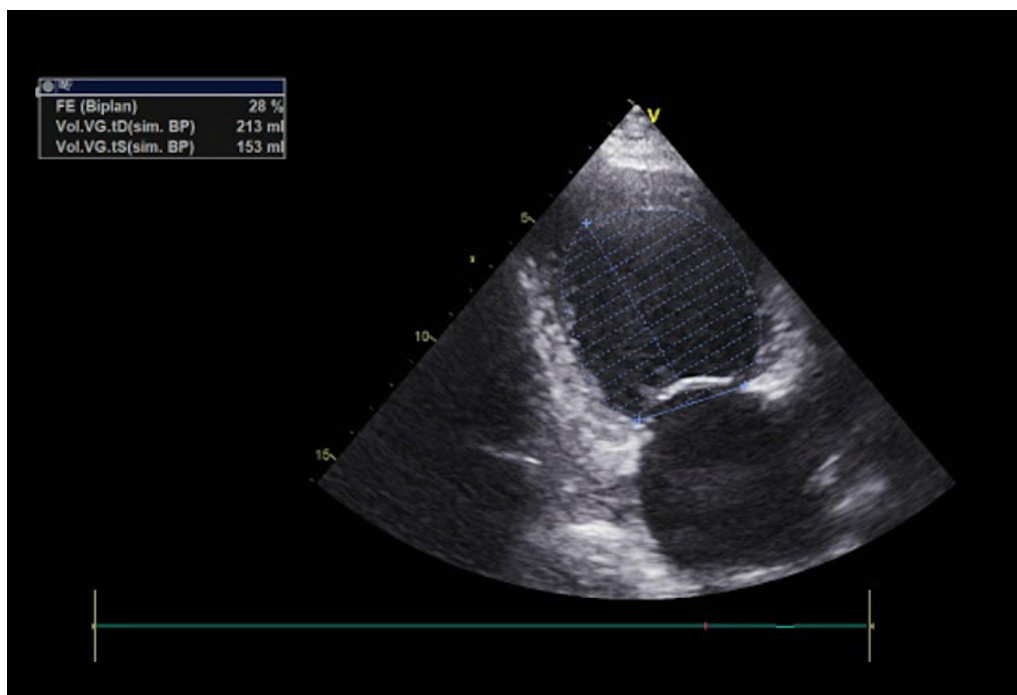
The echocardiography shows a depressed left ventricular ejection fraction (LVEF=28%)
